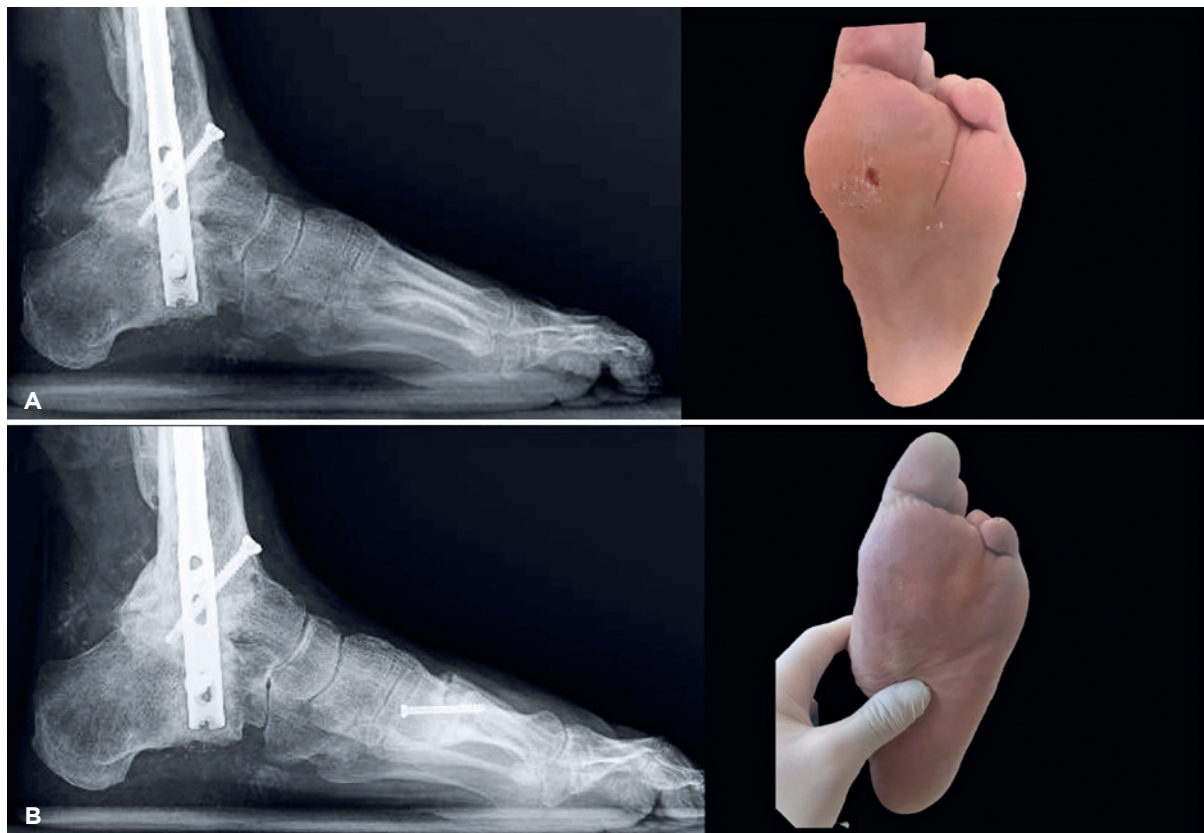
A. Plantar ulcer at the head of the first metatarsal and preoperative radiograph. B. Clinical and radiographic follow-up at three months postoperatively.
